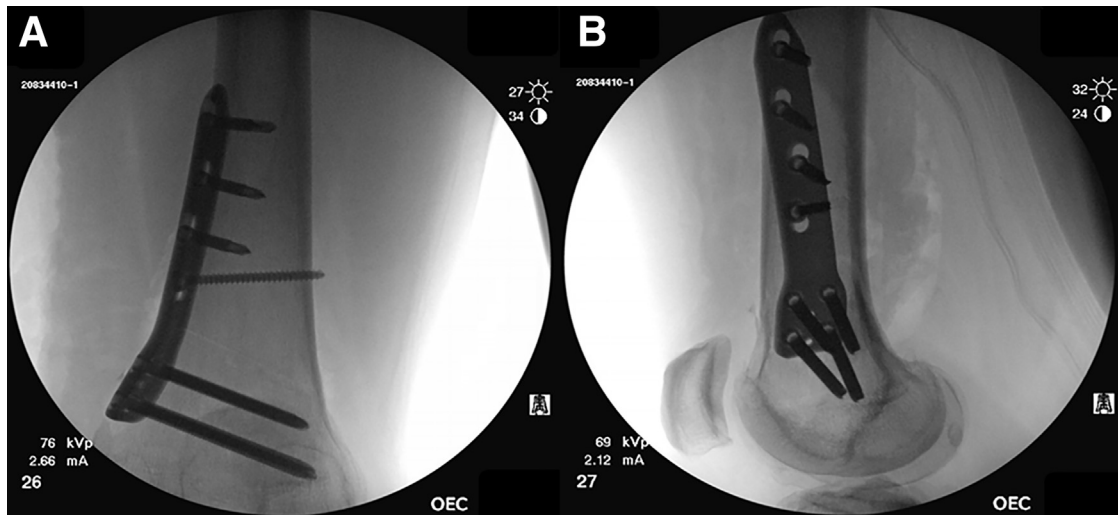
Final anteroposterior (A) and lateral (B) radiographs after locking plate application. Four cancellous self-taping unicortical locking screws are placed on the distal holes. An oblique 4.5-mm compression screw is then inserted aiming slightly proximal to achieve best interfragmentary compression. The remaining 3 proximal holes are then filled with unicortical locking screws.
